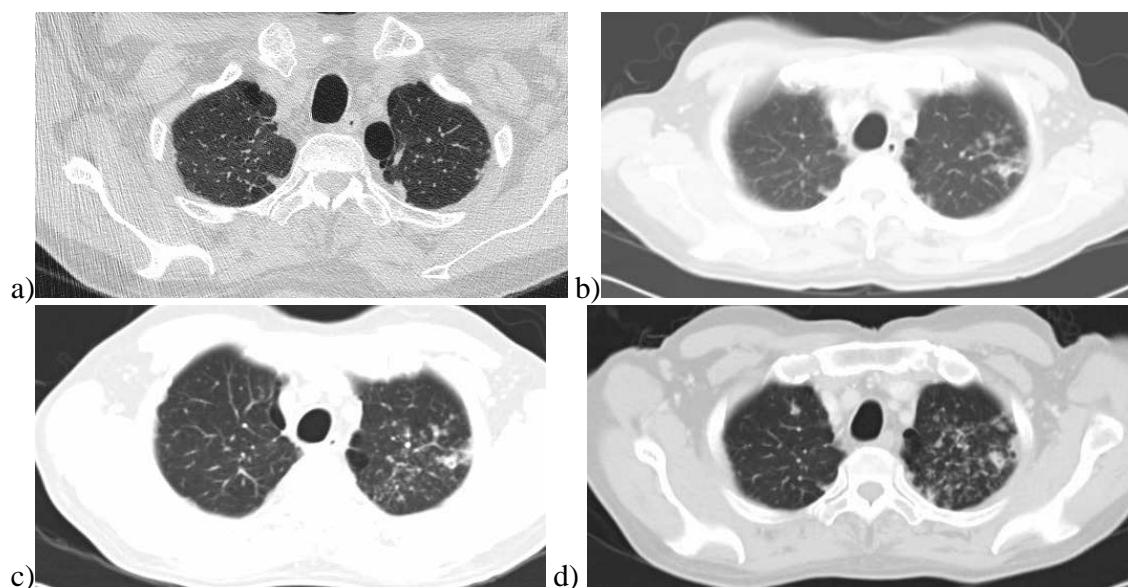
a) Baseline CT thorax during investigation for latent tuberculosis prior commencement of biologic agent b) initial CT Thorax which showed nodular lesions more over the left apical region c) follow up CT thorax due to the nodular lesion with positive aspergillus antigen which revealed increase nodular lesion and tree in bud lesion d) after 4 months of anti-fungal itraconazole 400 mg/day noted more cavitary lesion over previous area.
